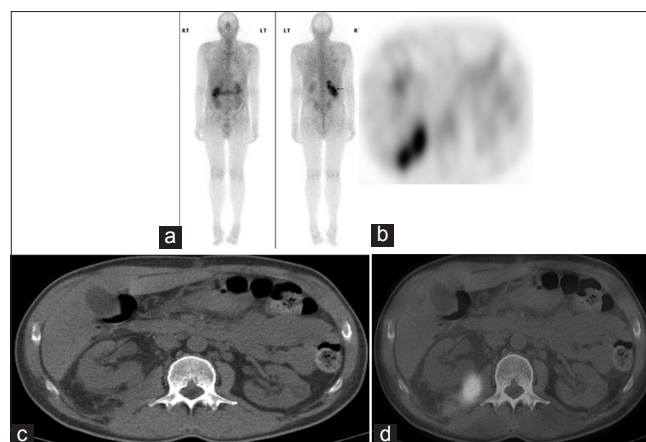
Ga-67 citrate study in a renal transplant recipient with fever of unknown origin (patient 17). The whole-body study (a) suggests uptake in the right posterior upper abdomen suspicious of infection in the native right kidney. A transverse SPECT (b), low dose CT (c), and fused SPECT/CT (d) were viewed. On SPECT/CT, abnormal uptake lies within the right psoas muscle and posterior pararenal space and is separate from the right kidney
